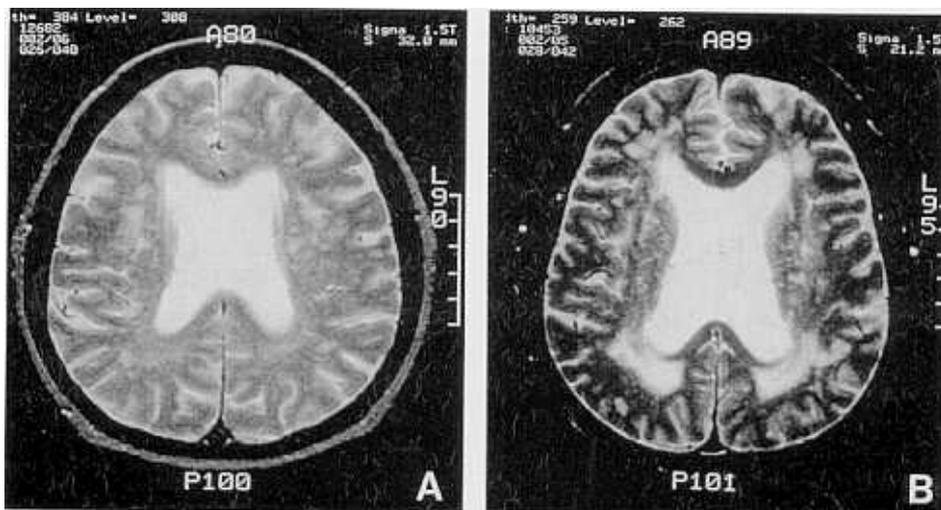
T2-weighted MRI (TR 2500 / TE 80 msec) indicates (A) deep hyperintensities (DH) and (B) periventricular hyperintensities (PH).
